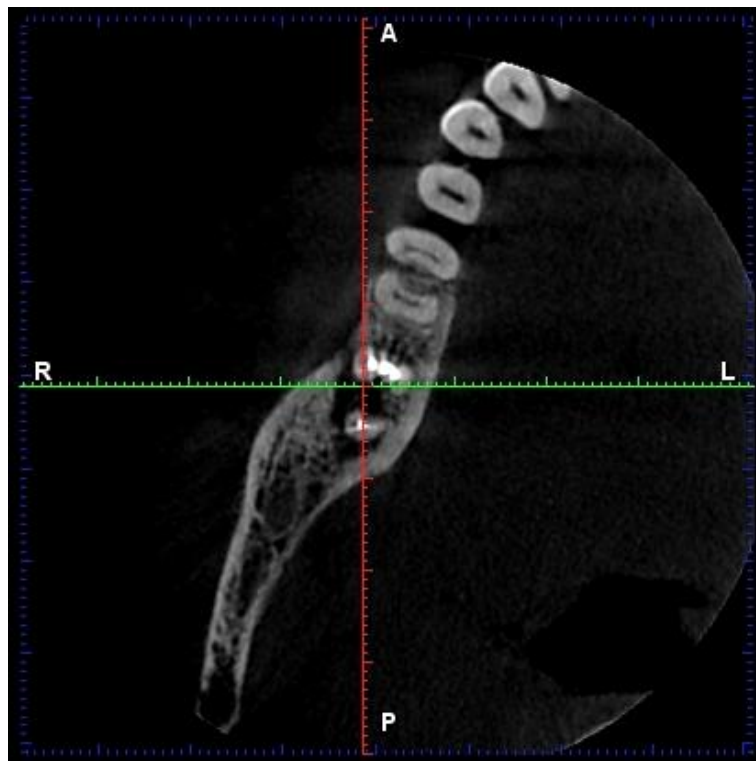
CBCT after obturation
